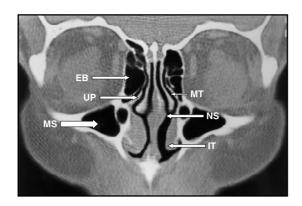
Coronal computerised tomography (CT) scan demonstrating normal sinus anatomy and mucosa. EB = ethmoid bulla; IT = inferior turbinate; MS = maxillary sinus; MT = middle turbinate; NS = nasal septum; UP = uncinate process.
